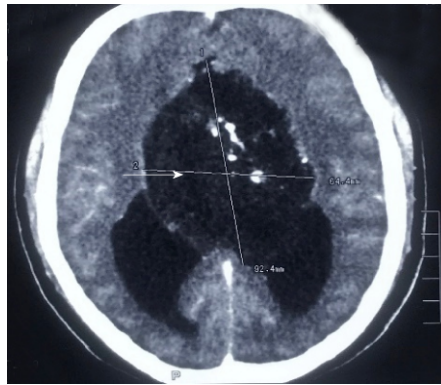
A contrast-enhanced computed tomography of the head demonstrates minimal perilesional enhancement. The lesion obstructs the hydrocephalus of lateral ventricles (Figure 2). The maximum size of lesion measures 77 mm × 57 mm on computed tomography scan.
